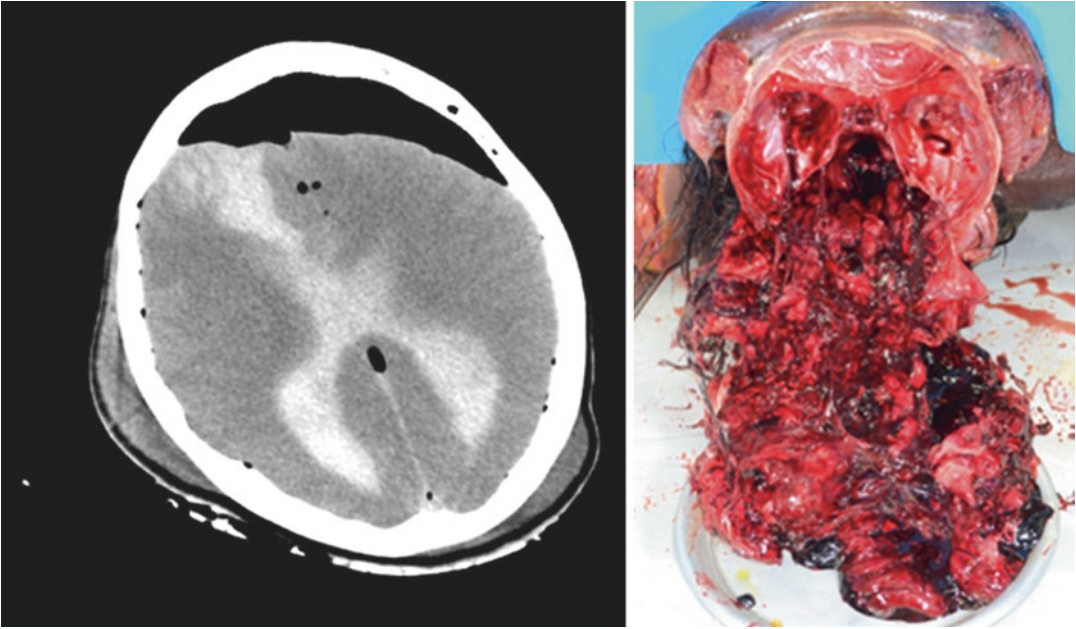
Axial brain computed tomography (CT) image and the autopsy image of the intracerebral hematoma found in the putrefied brain. Even in the putrefied
